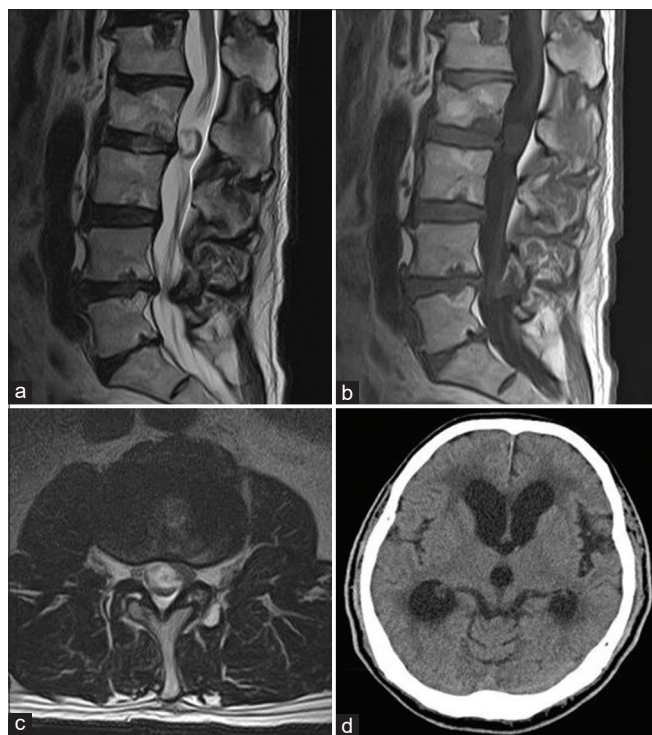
Radiographic findings of case 1. (a) T2 sagittal image showing an intradural extramedullary mass at the level of L2-L3. (b) T1 sagittal image. (c) T2 axial image. (d) Head computed tomography demonstrating enlargement of the ventricles.
